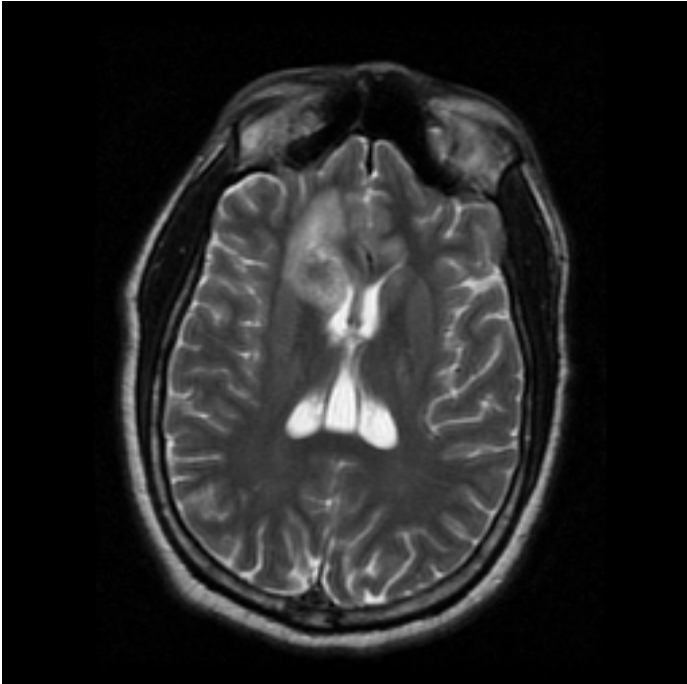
Brain MRI (T2 axial image) showing mass-like abnormal signal changes in right caudate nucleus, the right genu of the corpus callosum and periventricular white matter.
